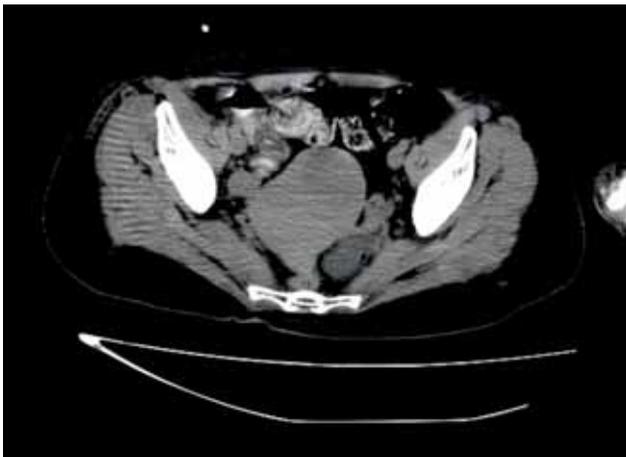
Native pelvic and abdominal CT – uterus increased in size, with smooth outlines. There is a 4.9 cm left annex cyst present, with no adenopathic nodules and no ascitic liquid
